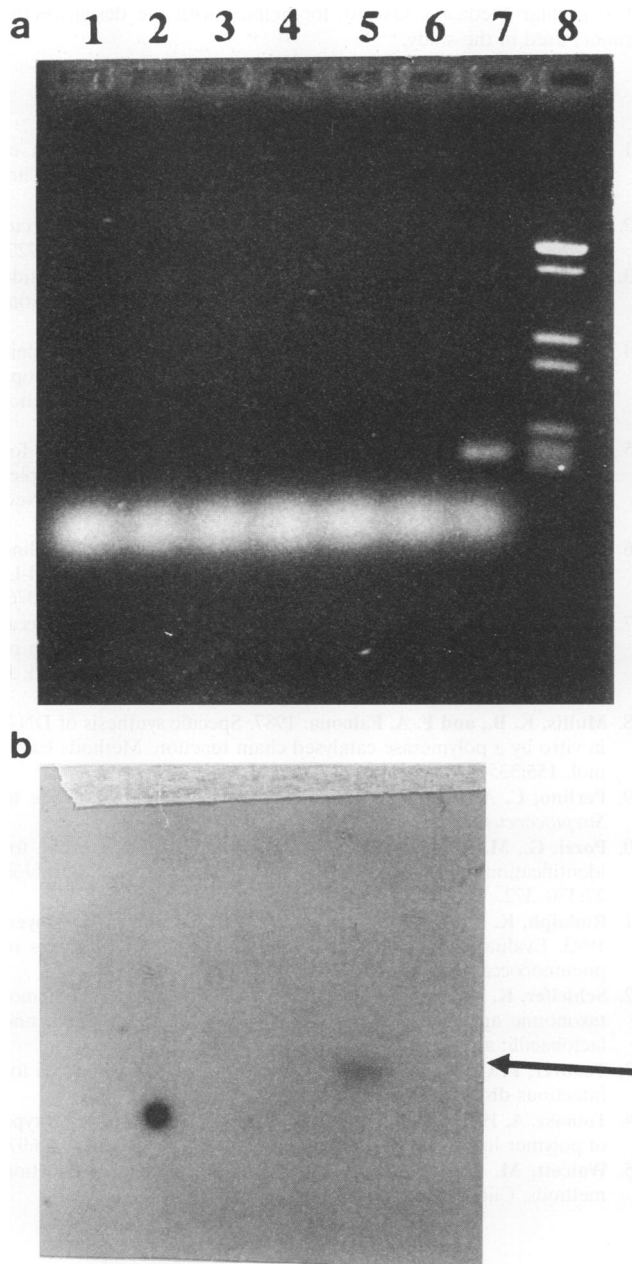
(a) Specificity of the PCR assay with DNA from various species of streptococci, analyzed by electrophoresis on a 1.8% agarose gel. Lanes 1 to 8, *S. pyogenes*, *Streptococcus faecalis*, *S. mutans*, *S. bovis*, *Streptococcus faecum*, *S. agalactiae*, *S. pneumoniae*, and molecular weight markers, respectively. (b) Autoradiography of panel a showing one positive signal with DNA from *S. pneumoniae* after hybridization with a 21-bp probe derived from sequences within the predicted 247-bp fragment. The probe was labelled at the 5' end with (γ - 32 P)ATP. Autoradiography was carried out at -70°C on a Kodak XAR-5 X-ray film for 48 h.
